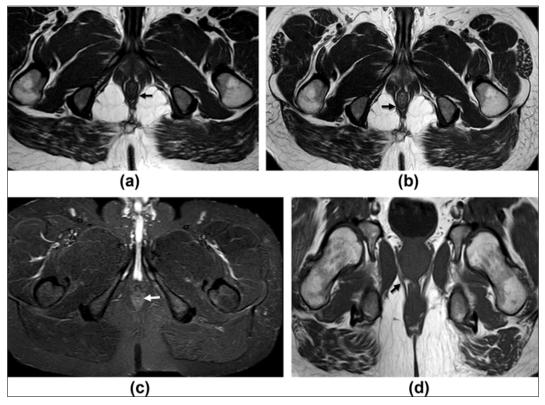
Images showing MRI anatomy of perianal region. The anal sphincter complex appears as muscular rings bounded laterally by ischioanal fat on both sides. The outer/external sphincter muscle appears hypointense on T1W (a) and T2W images (b). The inner/internal sphincter muscle appears hyperintense on T2W and (b) and fat-saturated images (c). The levator ani muscle forms the superior border of the ischio-anal fossa and merges inferiorly with puborectalis, which continues as the external sphincter muscle (d).
